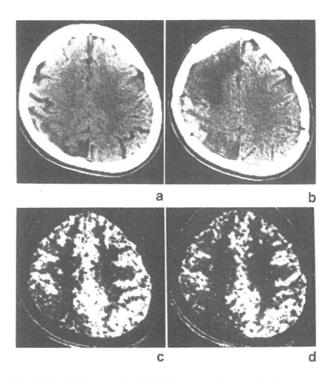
Case 1. Pre-operative CT (a) demonstrating atrophy following infarction at the right parieto-occipital region. CT (b) obtained after the second operation (left STA-MCA anastomosis) revealed an infarction in the right fronto-parietal region. Cortical hyperdensity is seen in the right parietal region. Pre-operative Xe-CT images at rest (c) and after acetazolamide (Diamox) challenge (d). Cerebral blood flow (CBF) is shown to be decreased at rest in the right hemisphere, especially in the right perieto-occipital region corresponding to the infarction shown in pre-operative CT. CBF is further decreased after Diamox challenge in the fronto-parietal regions bilaterally but predominantly on the right
